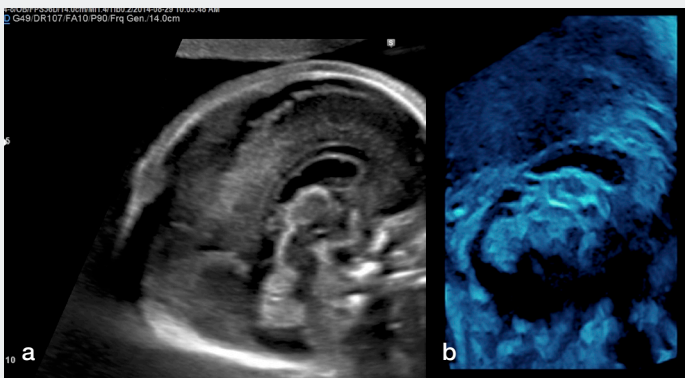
Ultrasound images showing cerebellar vermis obtained in the same fetus by 2D ultrasound (a) and 3D ultrasound (b).
